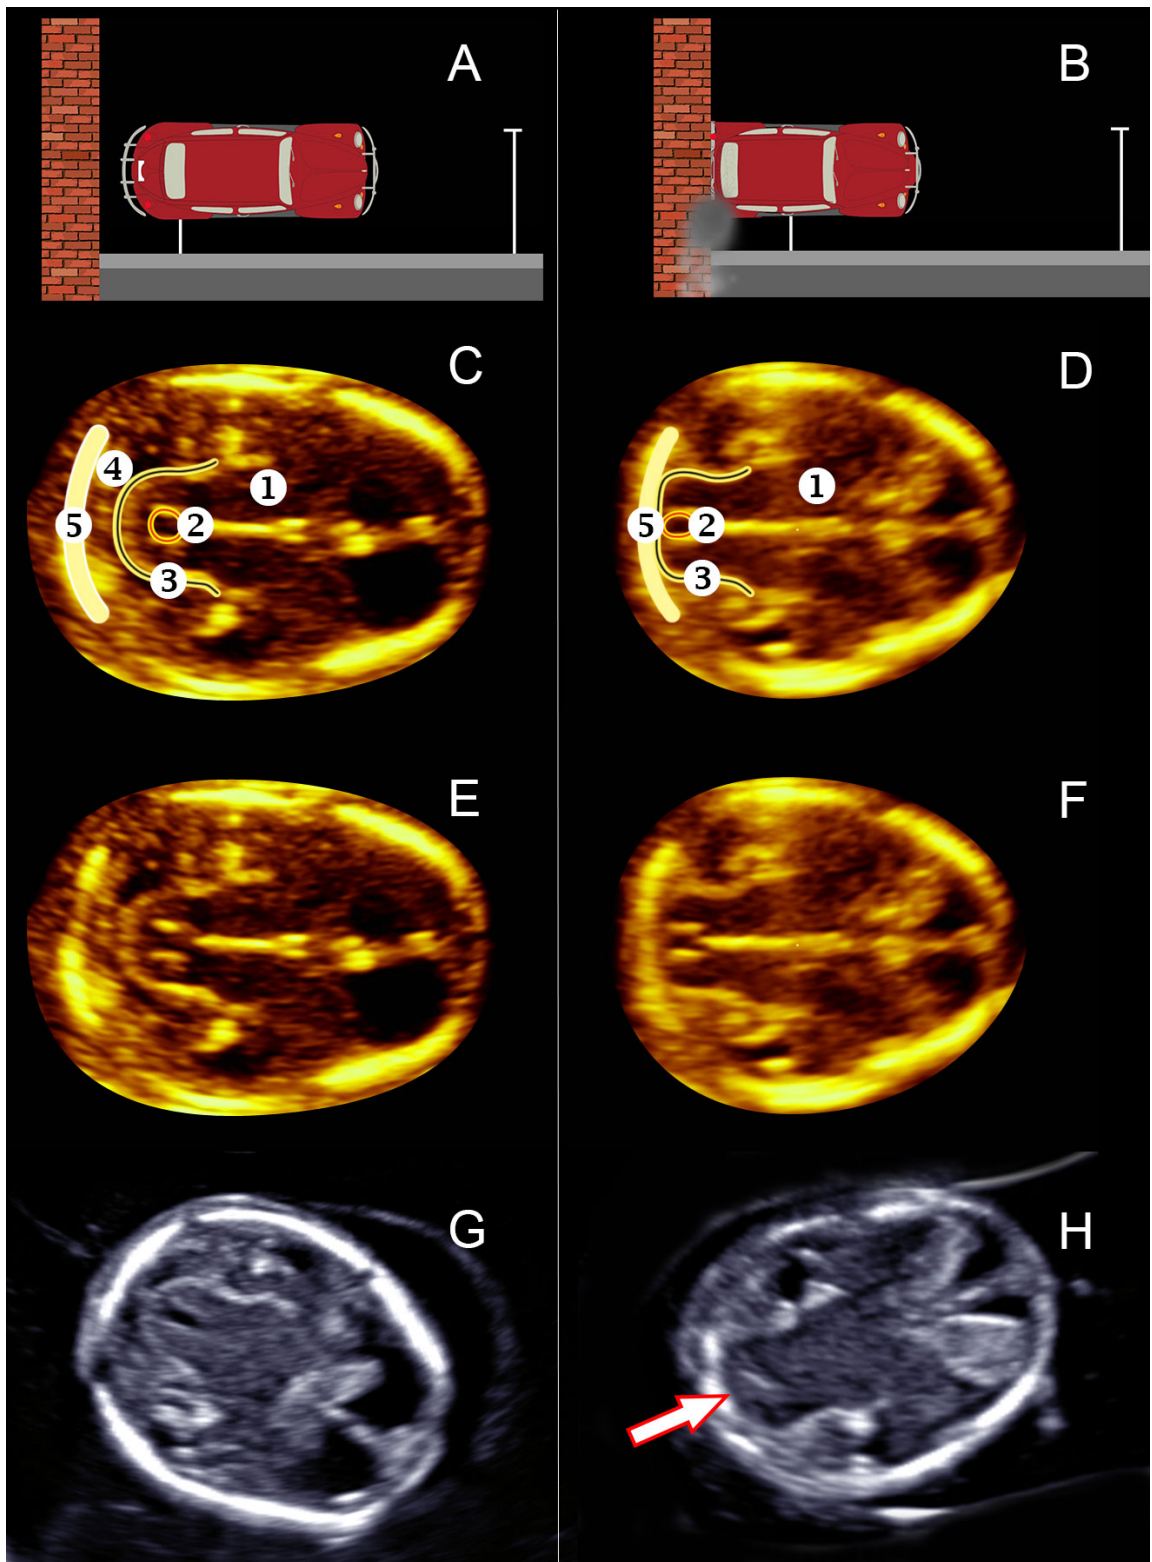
12-13 weeks ultrasound images of the mesencephalon in a normal fetus (left, C,E,G) and its posterior displacement and deformation against the occipital bone in a fetus with open spina bifida (right, D,F,H): the “crash sign”. C,D,E and F represent 3D reconstructed images of monozygotic twins, discordant for spina bifida. G represents a normal case; H shows the crash sign (arrow) in another fetus with spina bifida.
